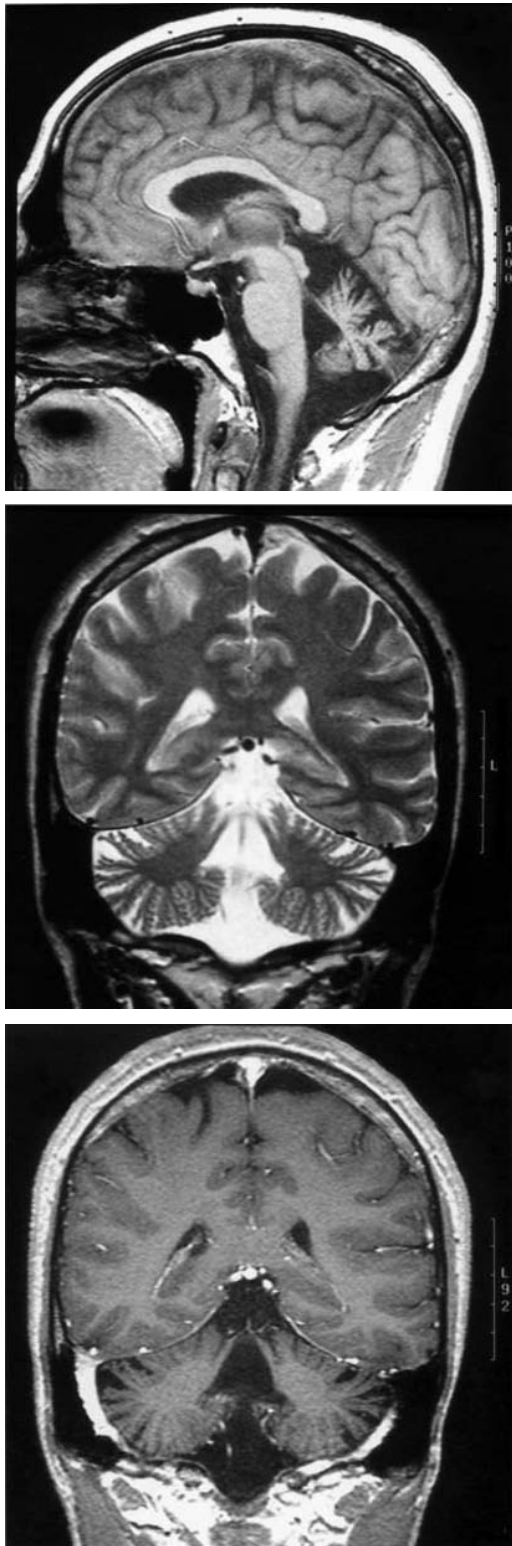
Sagittal T1-(top) and coronal T2- and T1-(middle, bottom, respectively) weighted magnetic resonance scans of a SCA5 patient with 4 years of disease duration showing severe atrophy of the vermis and hemispheres with sparing of the brainstem. Reproduced from Stevanin et al. (1999) Clinical and MRI findings in spinocerebellar ataxia type 5. *Neurology* 53: 1355–1357, with permission from Wolters Kluwer Health (<http://www.com>).
